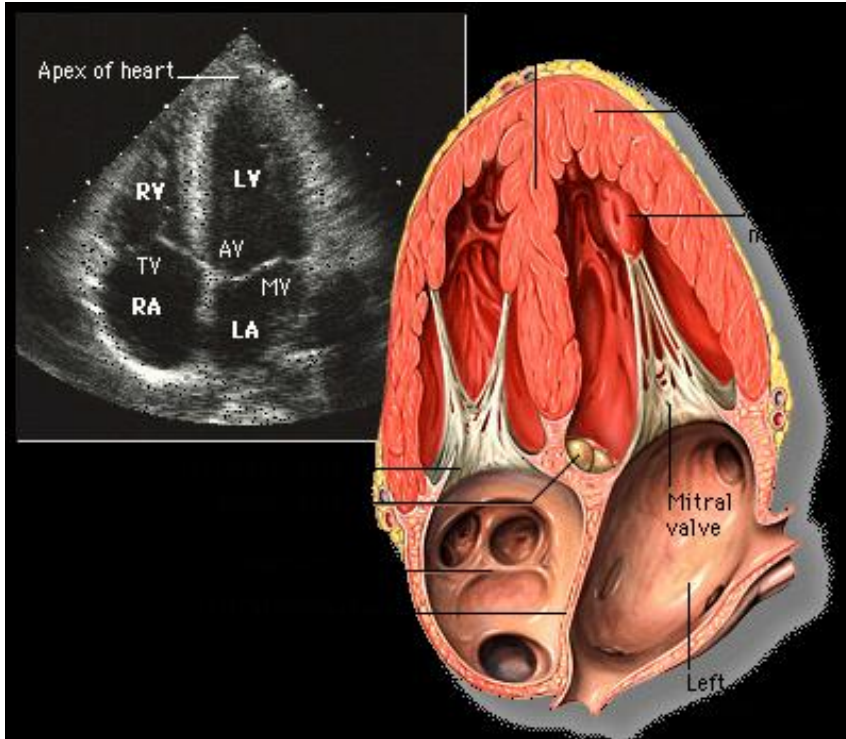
A cardiac ultrasound image showing all four chambers of the heart [27]
